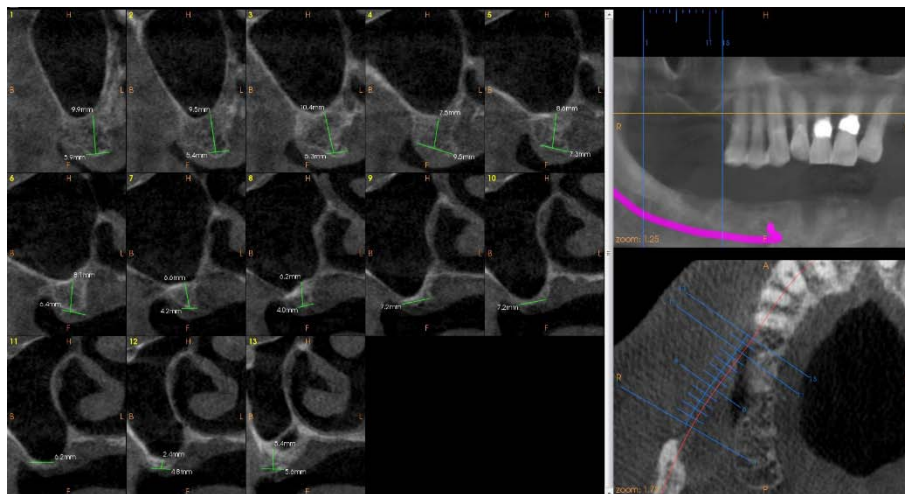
Shows the CBCT scan of maxilla preoperatively
